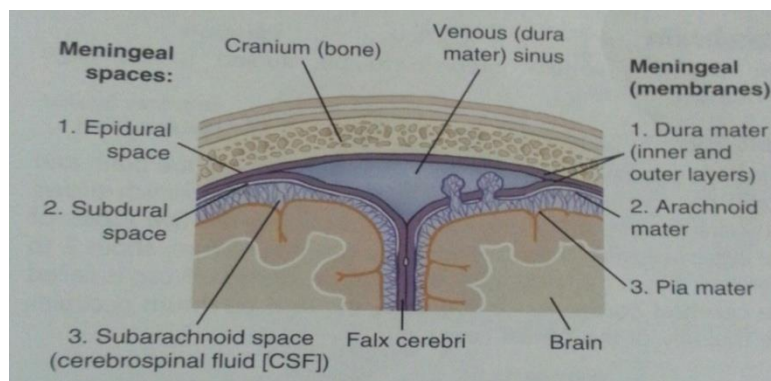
The brain (meninges) (Radiographic anatomy and physiology)
